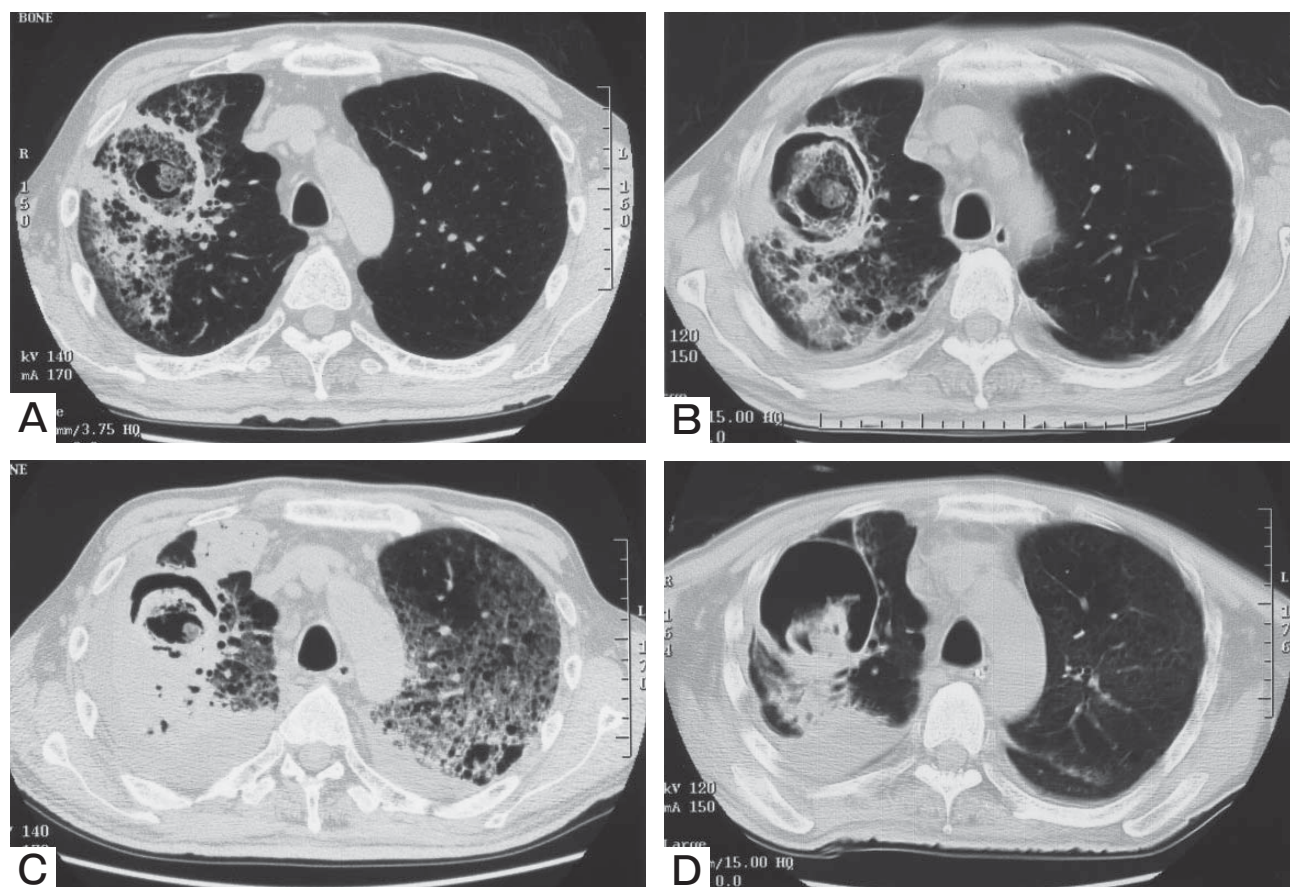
Chest CT scan showing cystic lesions and alveolo-interstitial infiltrates (A), air-space consolidation with air crescent sign and ground glass attenuation after 10 days (B), rapid progression of pulmonary infiltrates after 14 days (C), and a thick-walled cavitary lesion suggestive of aspergilloma after 31 days (D).
